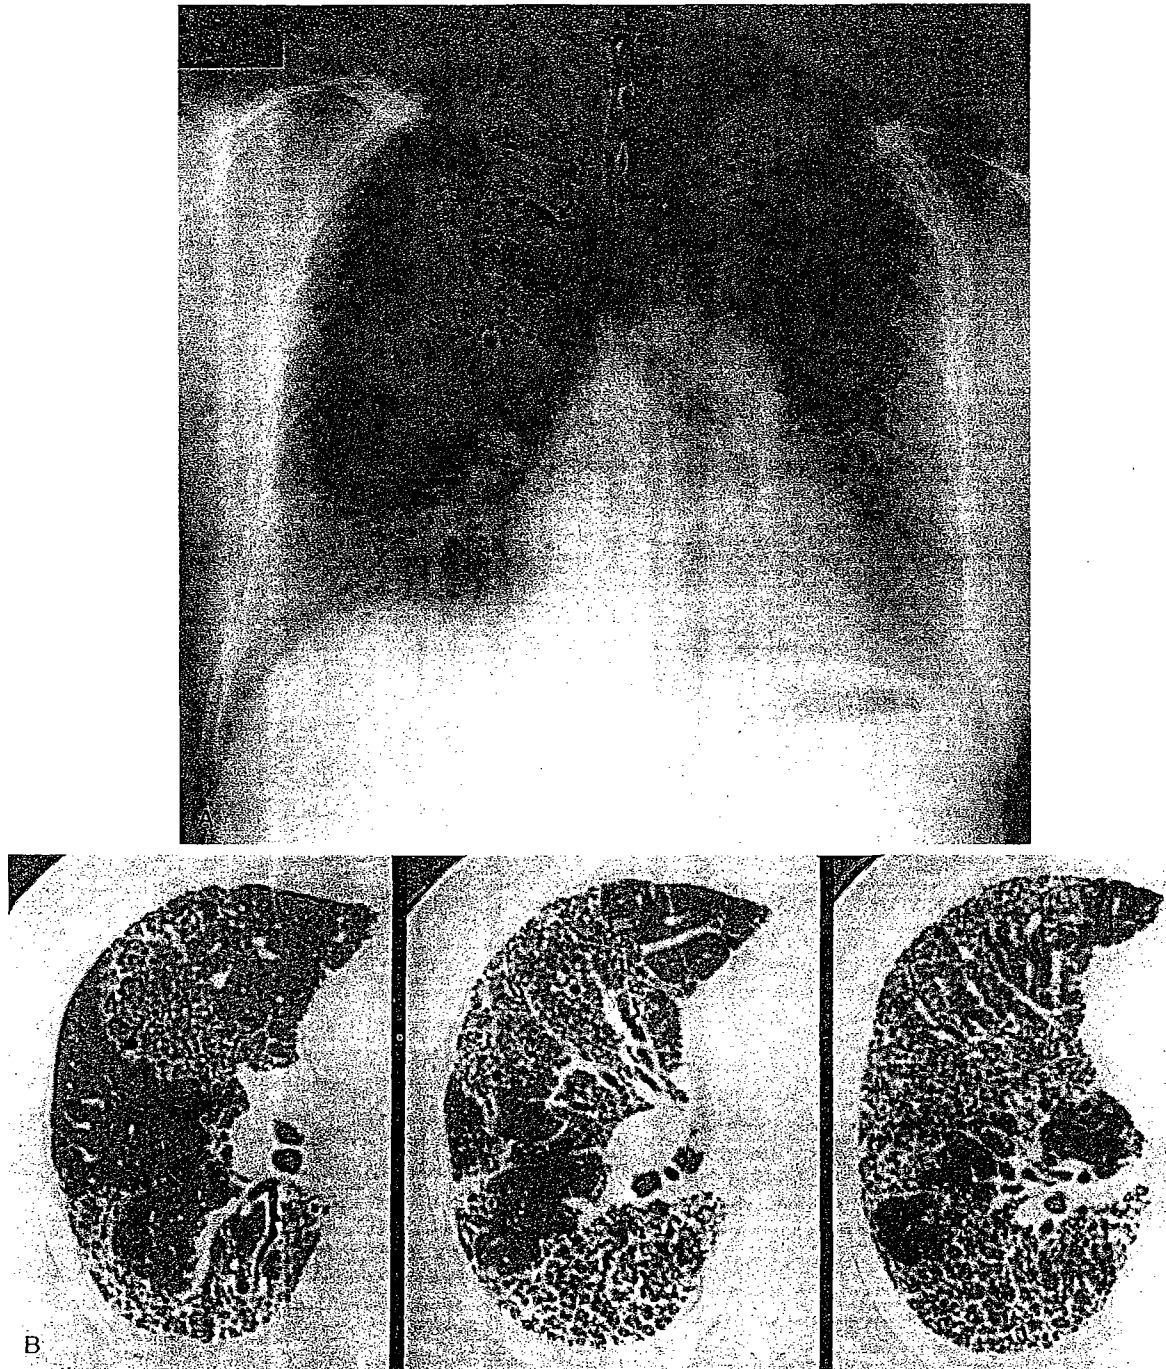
Aluminum Pneumoconiosis. A 52-year-old man with a history of exposure to aluminum for 7 years presented with exertional dyspnea. A posteroanterior chest radiograph (A) demonstrates a diffuse, bilateral reticular pattern. HRCT images targeted to the right lung (B) better demonstrate the reticular pattern and the presence of honeycombing. (Courtesy of Dr. Masanori Akira, Department of Radiology, National Kinki Chuo Hospital Chest Disease, Osaka, Japan.)
